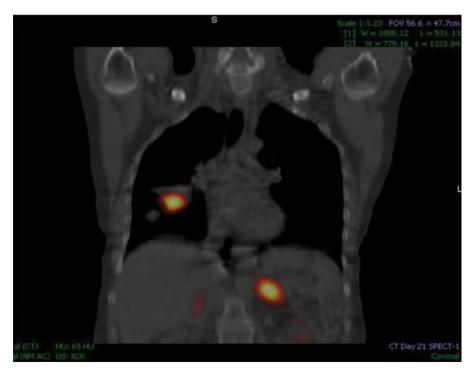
SPECT-CT fused images from a patient (100107) with lung and nodal metastases from colon cancer. Day 21 postinfusion coronal SPECT-CT demonstrating selective uptake of ¹³¹I-CLR1404 in known metastatic foci of a patient with colorectal cancer. Tumor signal was retained beyond 21 days (images not shown).
